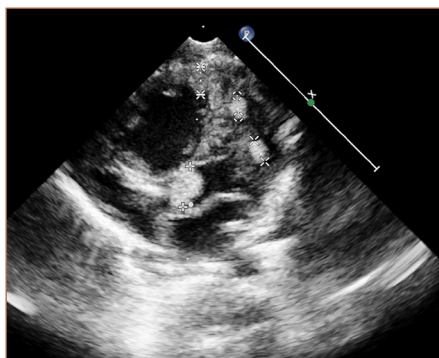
Echocardiographic image before treatment
